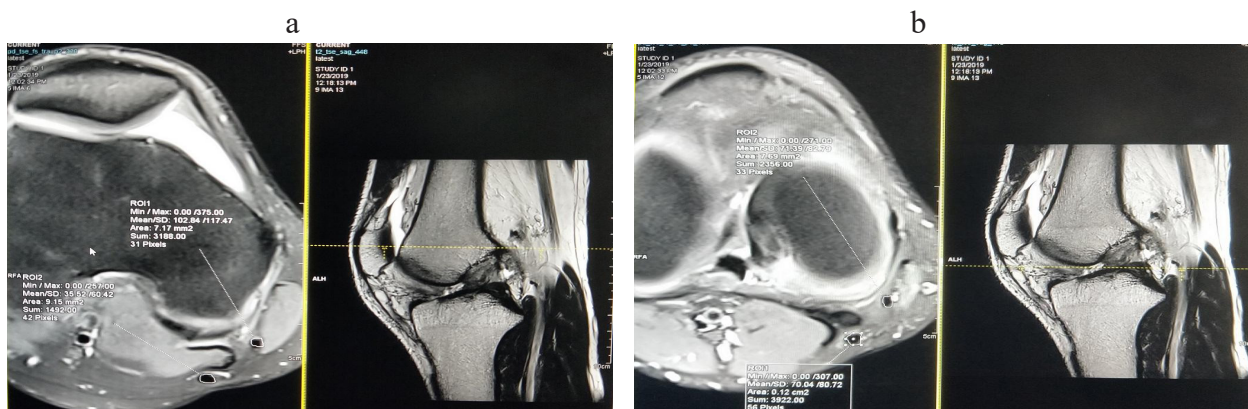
T2 weighted axial and sagittal MR images showing measurement of CSA of semitendinosus and gracilis at the level of (a) physal scar line and (b) the joint line.
